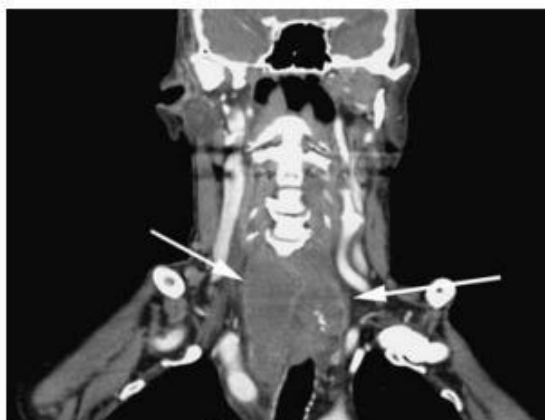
Coronal CT scan of the neck showing an abscess after endoscopic therapy.³
